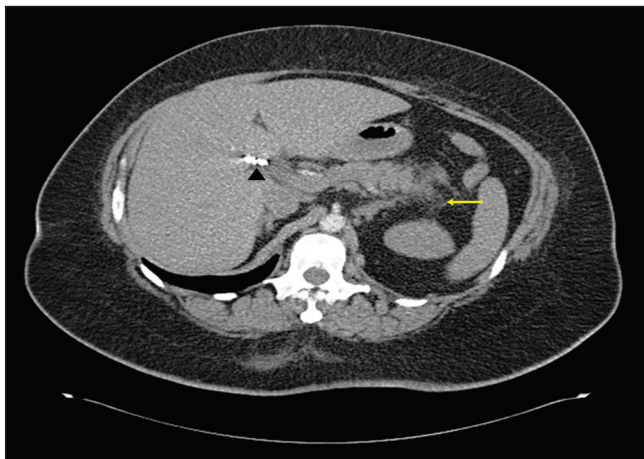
Contrast-enhanced computed tomography at the level of pancreas. Arrow in yellow color demonstrates peripancreatic fatty infiltration. Black arrowhead showed surgical clips in the gallbladder fossa indicating the patient’s status after cholecystectomy
